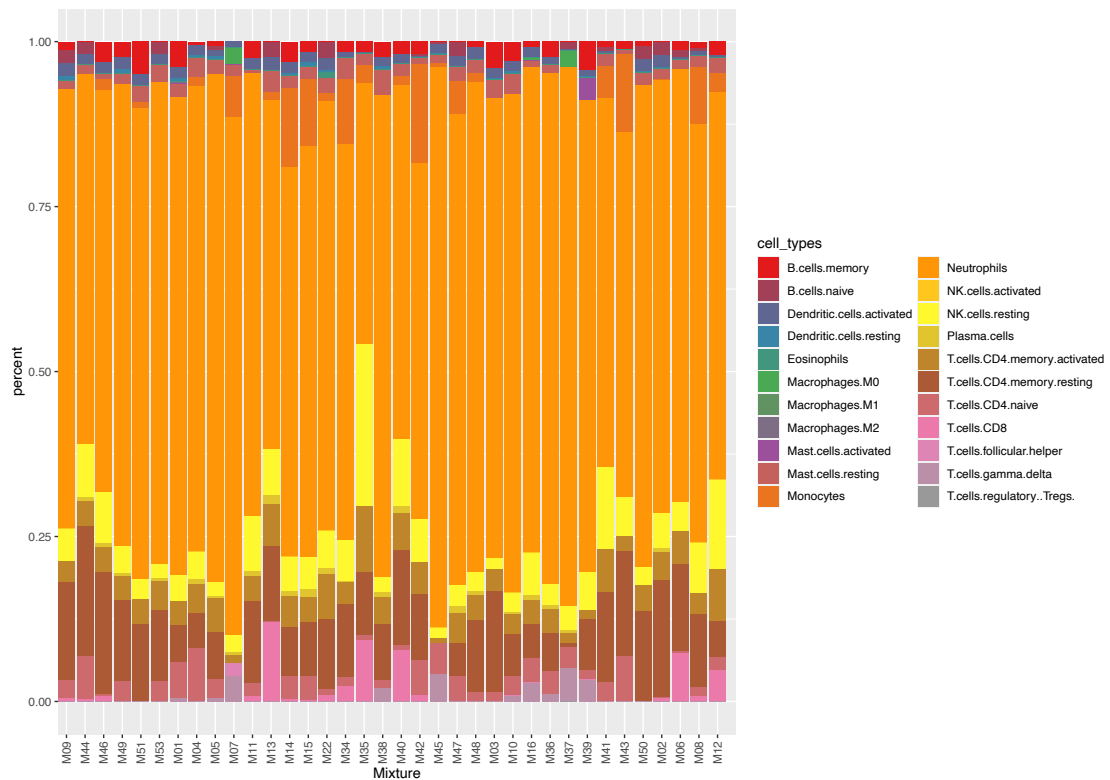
CIBERSORTx analysis of CT (upper) and PB (lower) samples
